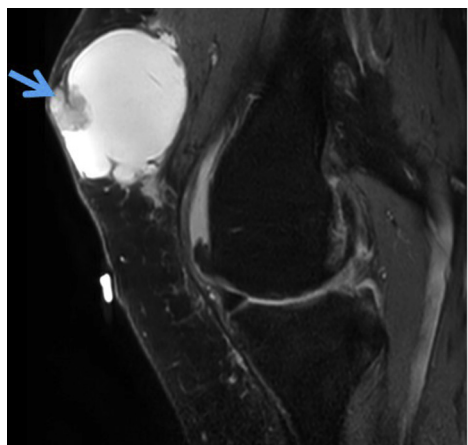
Sagittal MRI (T2-weighted with fat saturation) through the left knee; blue arrow indicates the cystic lesion with an irregular, enhancing mural nodule along its anterior wall (*arrow*).
